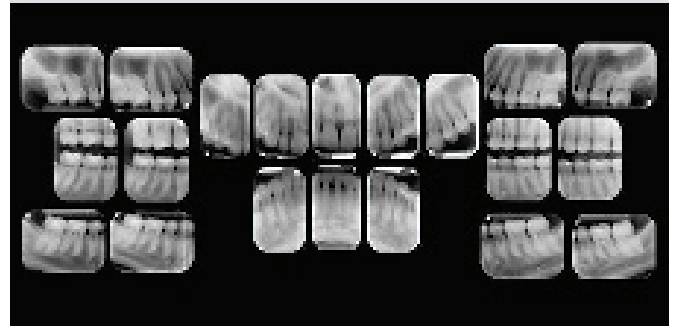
Full-mouth series radiographs.
